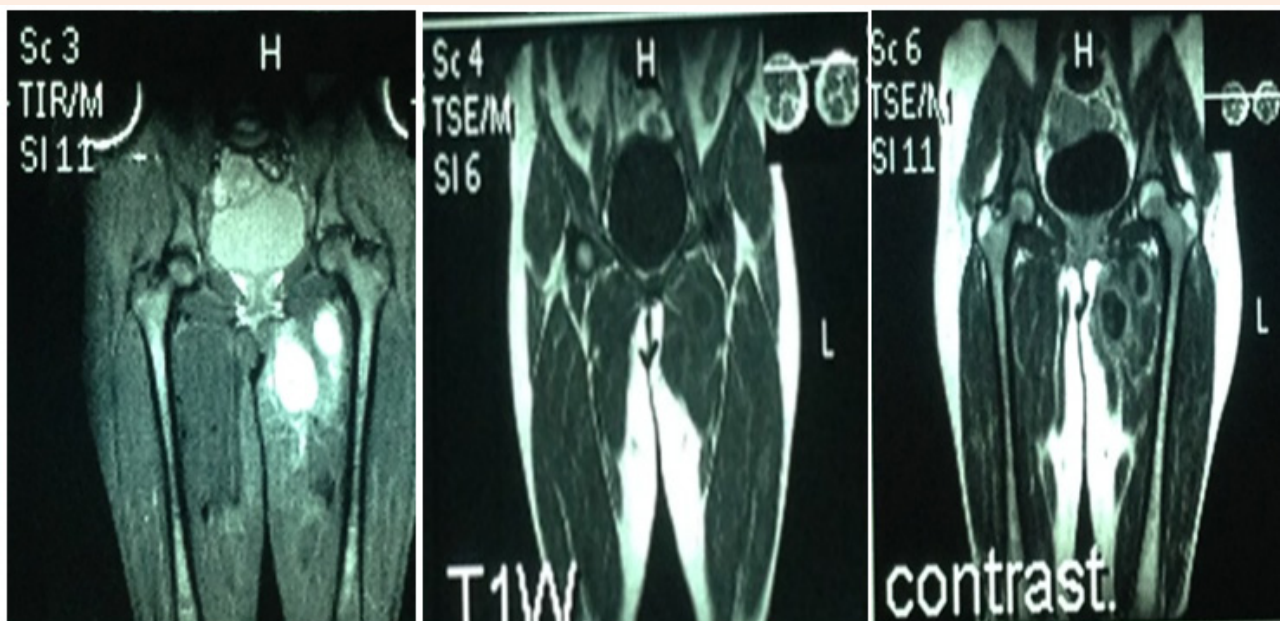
MRI demonstrated large intramuscular lesion with two cystic components within the left adductor magnus muscle.
